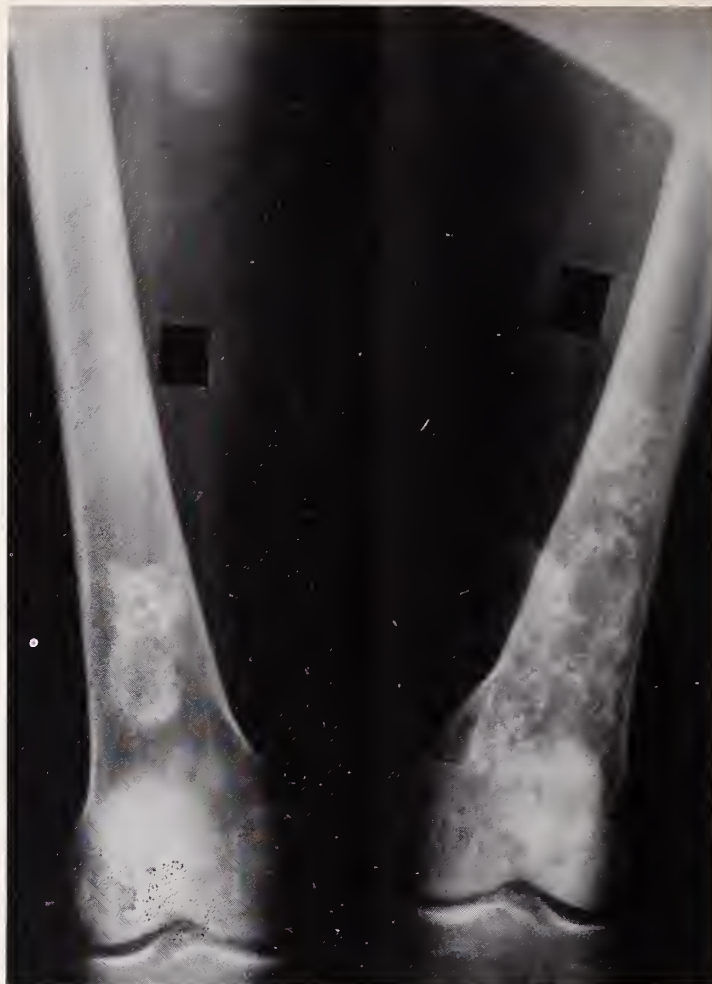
Roentgenographic appearance of osteonecrosis associated with pancreatitis and metastatic fat necrosis.
